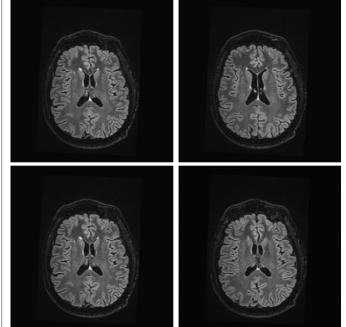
Magnetic resonance encephalography. Technique: Sagittal T1, axial T2, axial FLAIR, axial diffusion, axial SWAN and coronal T2. Report: There is no evidence of an intraparenchymal expansive process, extra-axial fluid collections, hypertensive ventriculomegaly, deviation of midline structures, effacement of base or focal areas of haemorrhage above or below the tentorium. There are no acute/subacute ischemic lesions detectable on the Echo-Planar sequence. The corpus callosum is well-formed, with an anatomical appearance. The ventricular system has normal topography, morphology and dimensions. The anatomical aspect of the basal cisterns and the convexity of the cerebral hemispheres. Rare small, circumscribed foci of T2/FLAIR hyper signal in supratentorial white matter periventricular and semioval centres, which do not determine a significant expansive effect or restriction to water diffusion, nonspecific, but which may represent foci of gliosis and/or myelin rarefaction. The normal signal strength of the rest of the white and grey matter in the brain. There were no signs of hippocampal sclerosis or hypothalamic lesions. Habitual flow at the level of the great arteries of the vertebrobasilar and carotid systems, according to the spin-echo criterion. Normal transparency of the visualized portions of the sinuses.
